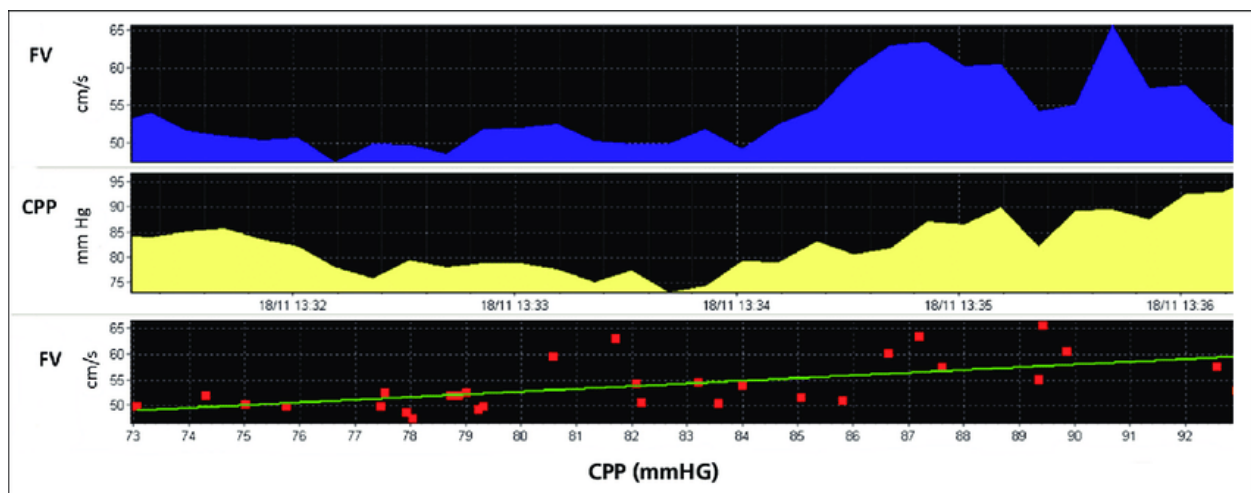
Dynamic Changes in Flow Velocity and Cerebral Perfusion Pressure. Captured during a transcranial Doppler recording for a single TBI patient over 5 minutes. Cerebral autoregulation can be approximated by a calculation of  $M_x$  from the correlation coefficient between mean FV and CPP, here the  $M_x$  value is positive (0.73), denoting disturbed autoregulation).
